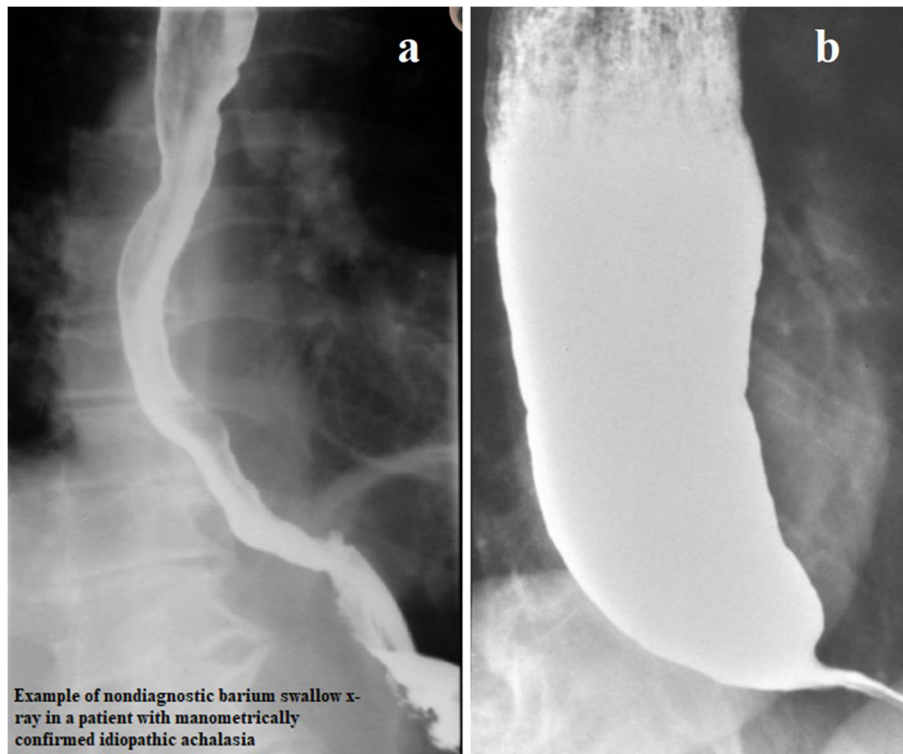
(a). From an article by El-Takli et al signed by the authors [26]. This X-ray does not show any of the signs of EA: the esophagus is not dilated, the LES is not contracted, evacuation to the stomach is not disturbed, and there is a large gas bubble in the stomach. In contrast, the esophagus is unevenly narrowed with irregular contours, which is strong evidence of esophagitis. (b). Typical picture of idiopathic achalasia.
